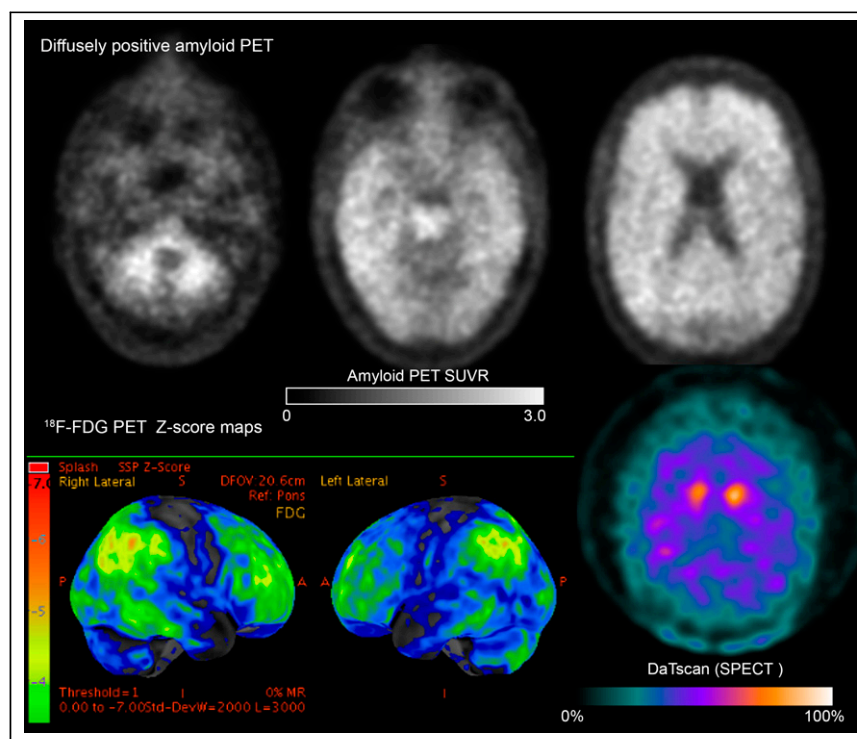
Pitfall of diffusely positive amyloid PET in dementia with Lewy bodies. (Top row) ^{11}C -PIB PET is positive and shows diffuse loss of gray–white contrast in both cerebral hemispheres. (Bottom row) ^{18}F -FDG PET z score map (left and center) in same person shows hypometabolism in occipital lobes, atypical region for AD, in pattern suggestive of dementia with Lewy bodies. ^{123}I -ioflupane SPECT (DaTscan; GE Healthcare) is abnormal (right), further supporting diagnosis of dementia with Lewy bodies, which was ultimately confirmed at autopsy. In non-Alzheimer neurodegenerative pathology, presence of diffuse plaques without neuritic components may still be associated with abnormal amyloid PET. SUVR = SUV ratio.
